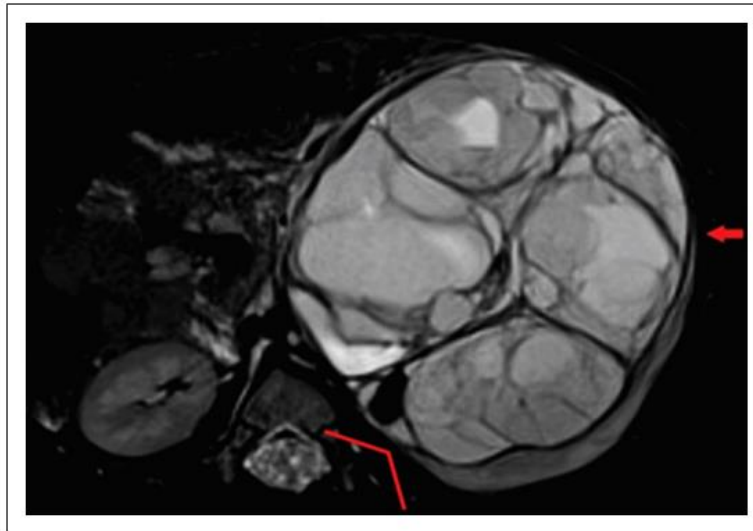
Axial fat-suppressed T2-weighted magnetic resonance image of a large cystic nephroblastoma arising from the left kidney. The claw sign is positive with tapering (red arrow), absent infolding and obtuse external kidney–tumour interface (red marker).
